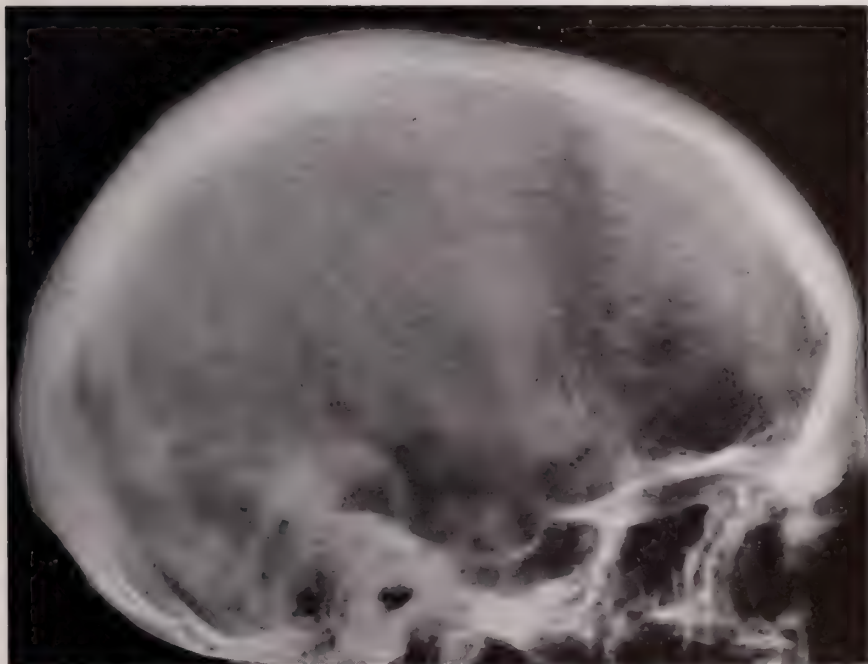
Gaucher's Disease?* This is the skull of a patient whose long bones were the sites of extensive involvement by Gaucher's disease. There are numerous small localized areas of radiolucency in the parietal bone. In the frontal bone there is a poorly defined area of mottled osteoporosis. This examination was part of a skeletal survey. The patient was not available later for more detailed roentgen study. These findings are not considered conclusive.
